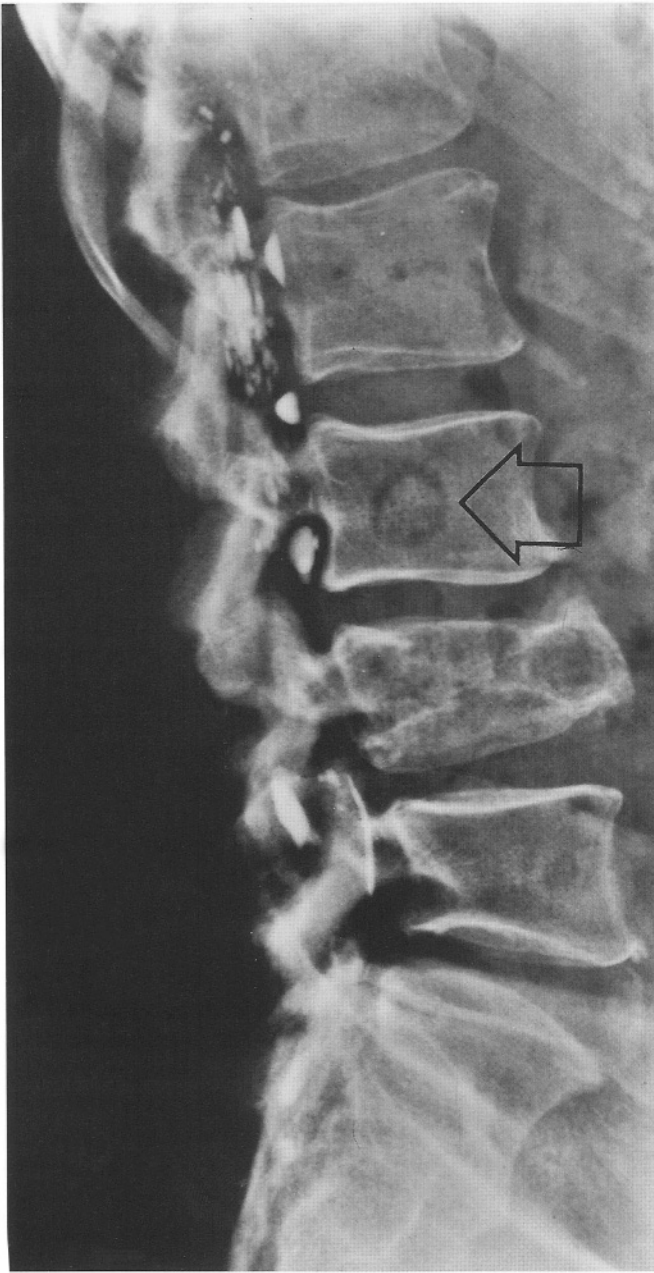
Lateral plain radiograph of the lumbar spine, showing metastatic high-grade osteosarcoma to the body of L3 vertebra (arrow).
